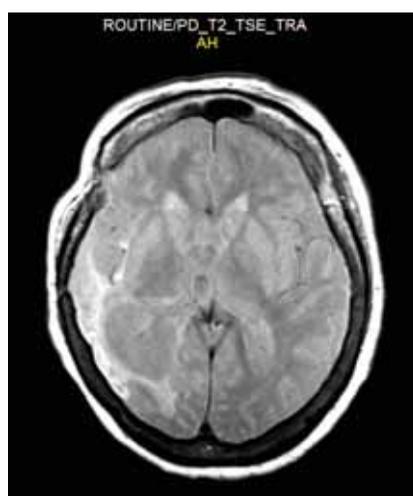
T2 axial and T1 coronal MRI showing a postoperative scar for right fronto-temporal cavernoma, enlarged asymmetrical lateral ventricles and cortical atrophy
